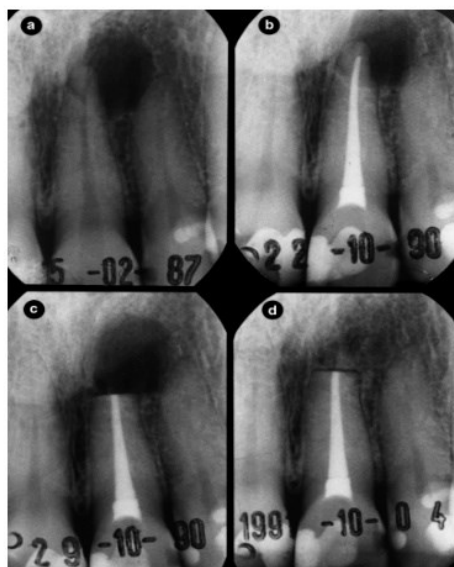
depicting the healing of periapical tissue after surgery (a) before treatment (b) after endodontic therapy (c) 3 months after root resection (d) 4 years recall pic courtesy: Nair et. al
